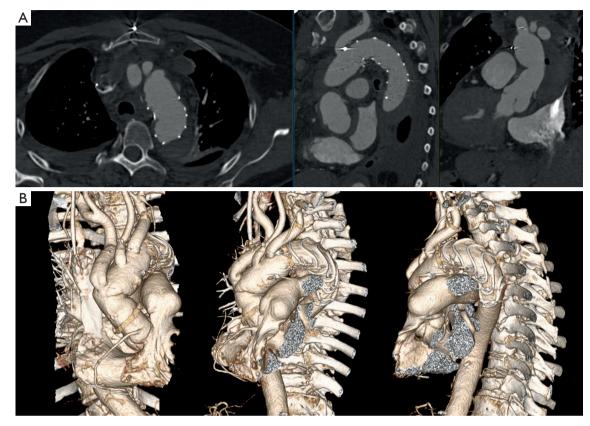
Postoperative result. (A) Postoperative CTA shows intended position of the FET graft in the descending aorta. (B) CTA 3D reconstructions after aortic root reconstruction using the neomedia technique and total aortic arch repair with a branched FET graft. CTA, computed tomography angiography; FET, frozen elephant trunk.
